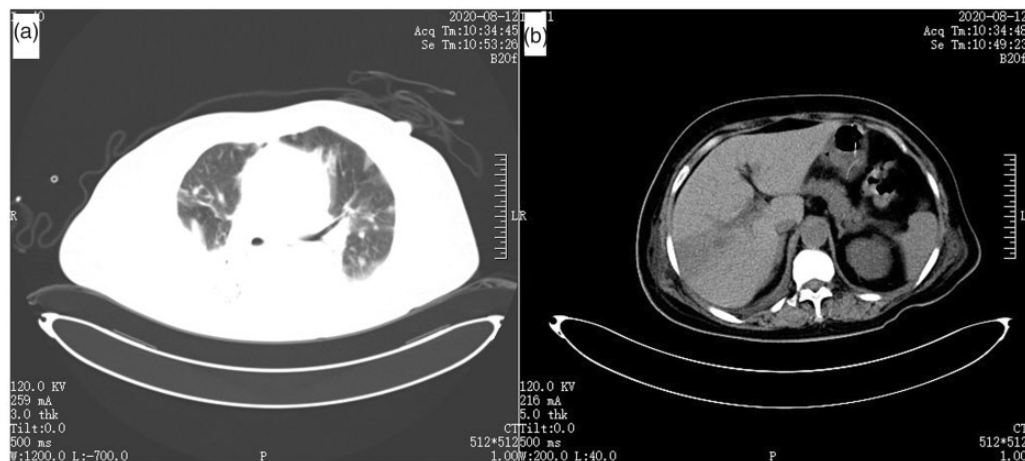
Computed tomography findings of the patient on the sixth day of admission. CT scan showing the improving lung infection (a) and hepatic abscess (b). CT, computed tomography.
